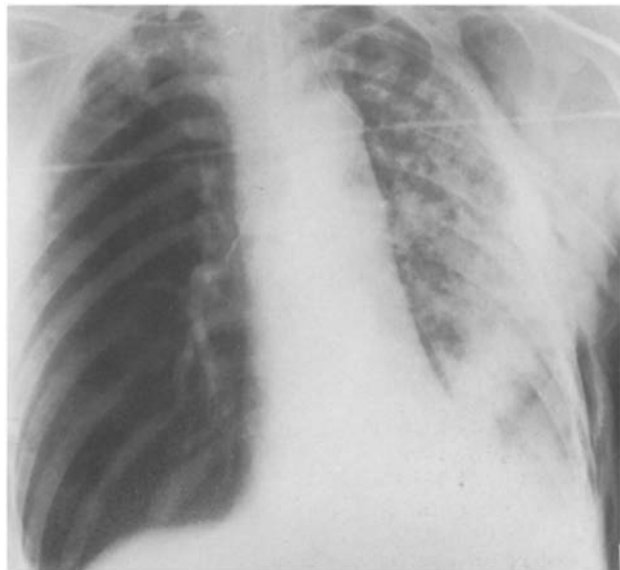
Chest X-ray showing partial re-expansion of left lung
